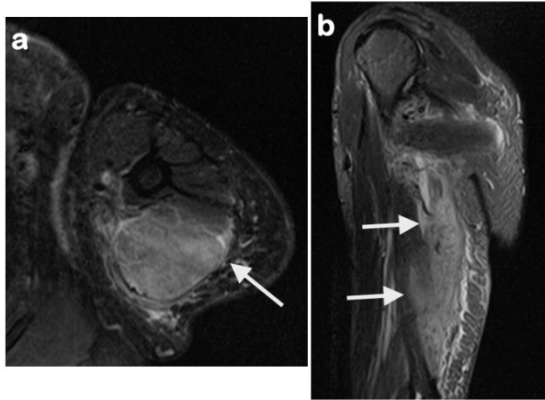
T2-weighted MRI sequence in axial (a) and sagittal (b) planes demonstrate an increased signal in the left triceps brachii muscle (white arrow)
